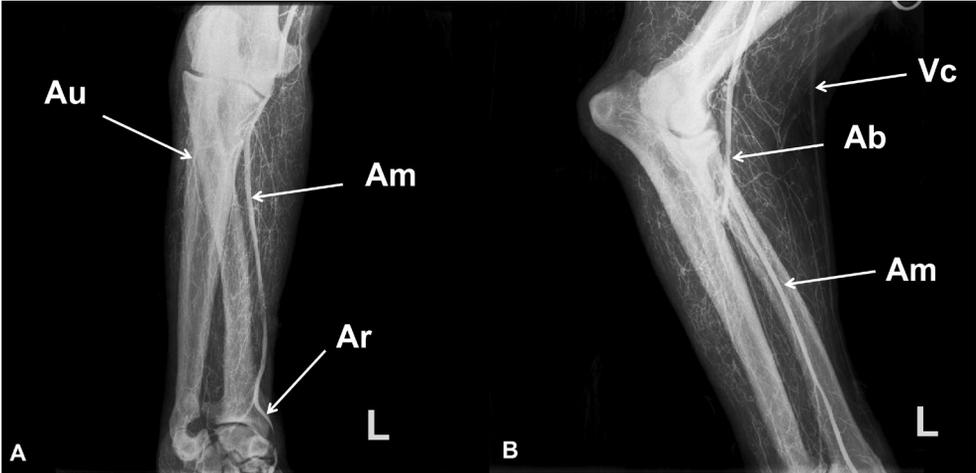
Radiographic image of the Brown bear thoracic limb; A – cranio-caudal projection; B – medio-lateral projection; Au – a. ulnaris, Am – a. mediana, Ar – a. radialis; Vc – v. cephalica, Ab – a. brachialis
